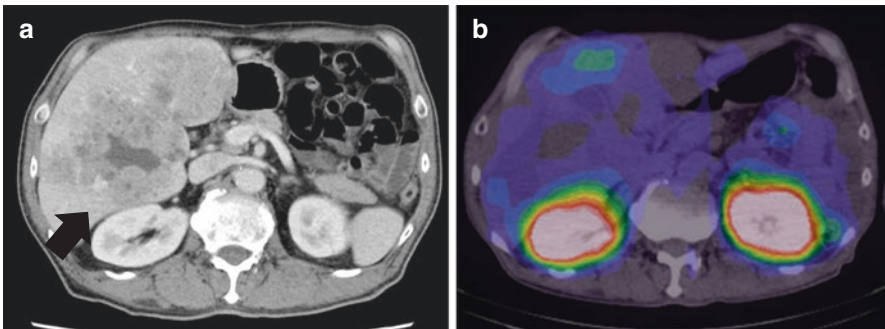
A 60s' male with multiple liver metastases from primary unknown G3 NET. (a) A contrast-enhanced CT image depicts poorly enhanced irregular-shaped lesions in the right hepatic lobe (arrow). (b) Somatostatin receptor scintigraphy (SRS) (24 h after the injection) reveals weak expression of receptors on these lesions, indicating that lesions are poorly differentiated. (c) An FDG/PET fusion image shows strong uptake in these lesions, suggesting their high metabolic activity
